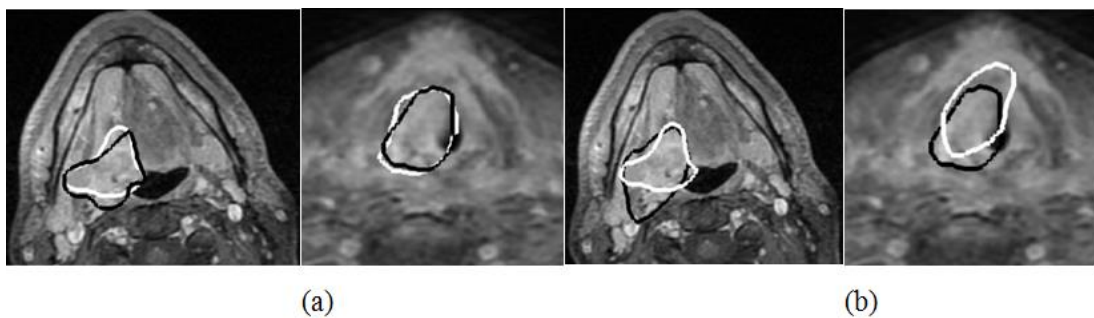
(a) Delineation by two clinicians and the intra- variability (b) Delineation by one clinician before and after a period of time and the inter-variabilities (white and black contours) in GTV of base of tongue (BoT) and larynx tumour from MRI (provided by Beatson Cancer Centre) [55].
